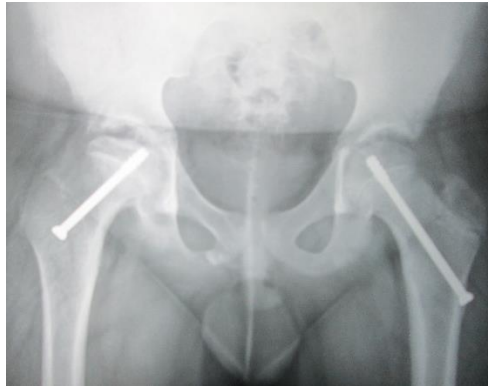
Pelvis x-ray showing bilateral pinning of slipped upper femoral epiphysis. The x-ray was done six months after surgery.
